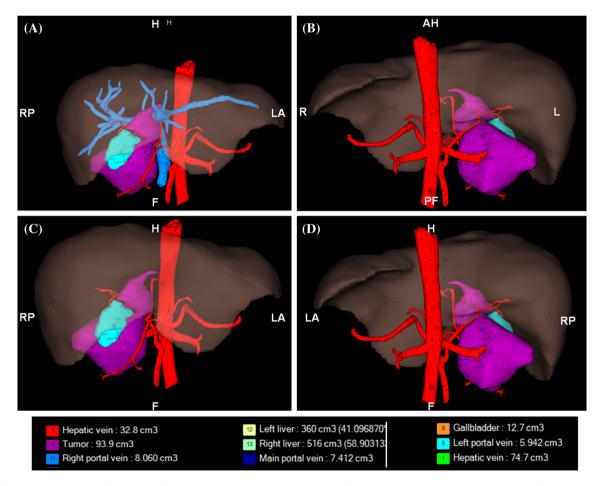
Preoperative three-dimensional CT reconstruction showing the extent of the lesion and its anatomical relationship with the hepatic arteries and portal vein
